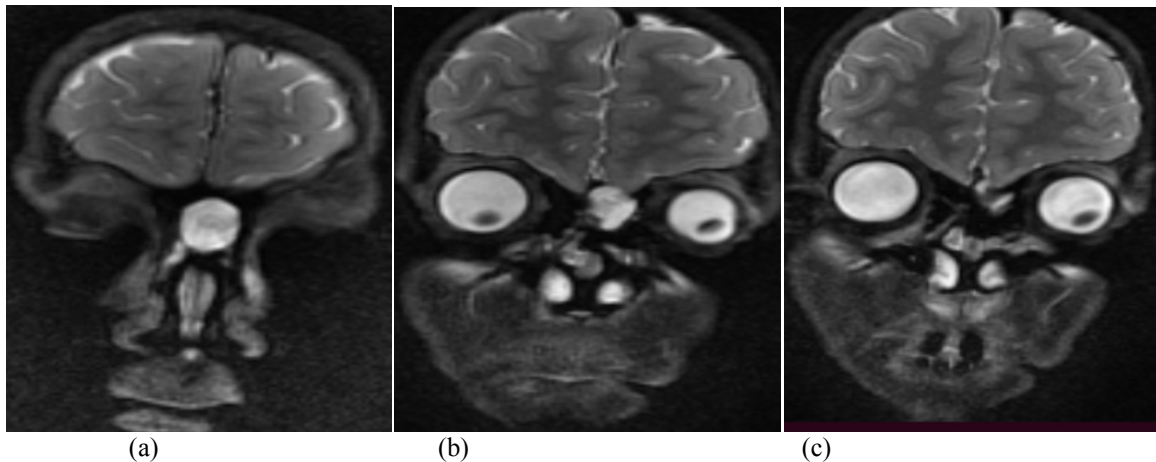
Sequential(anterior to posterior) Coronal T2 weighted MRI images showing well defined T2 hyperintense lesion in frontonasal region causing mass effect on left basifrontal region with minimal intracranial extension along the floor of left anterior cranial fossa through a focal defect in cribriform plate.
